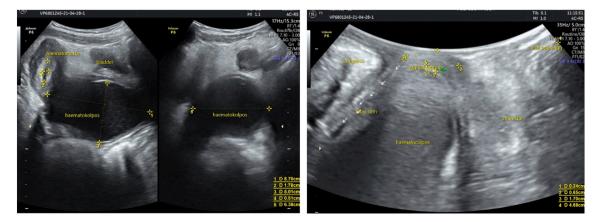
Ultrasound evaluation of first case. Note the vaginal septum located very distally.
